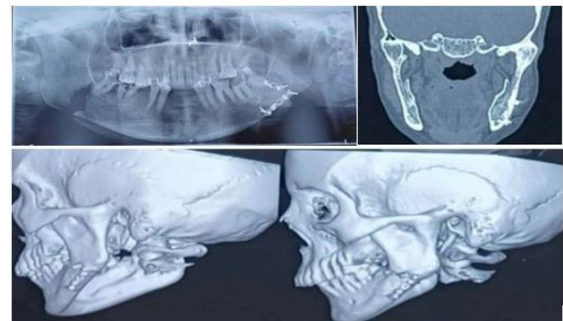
Preoperative Orthopantomogram showing mini plates over left angle region and obliteration of joint space bilaterally. Preoperative CT images of different sections along with 3D reconstruction.
